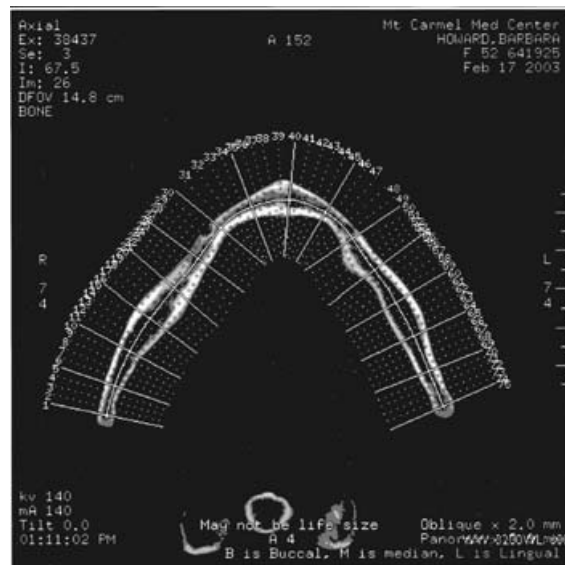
A CT scan is used to assess ridge width and mental nerve positions.
